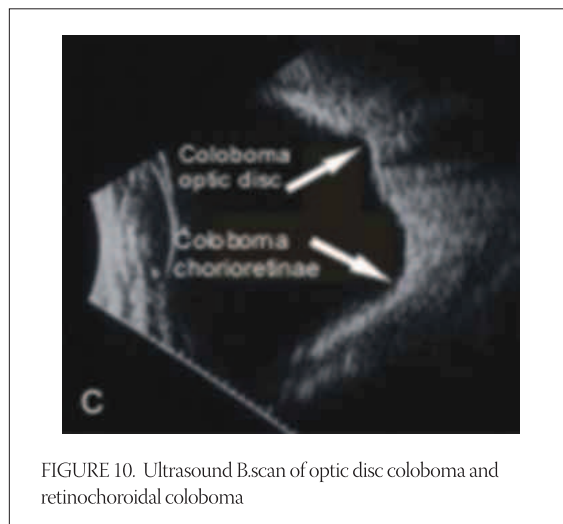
Ultrasound B.scan of optic disc coloboma and retinochoroidal coloboma
